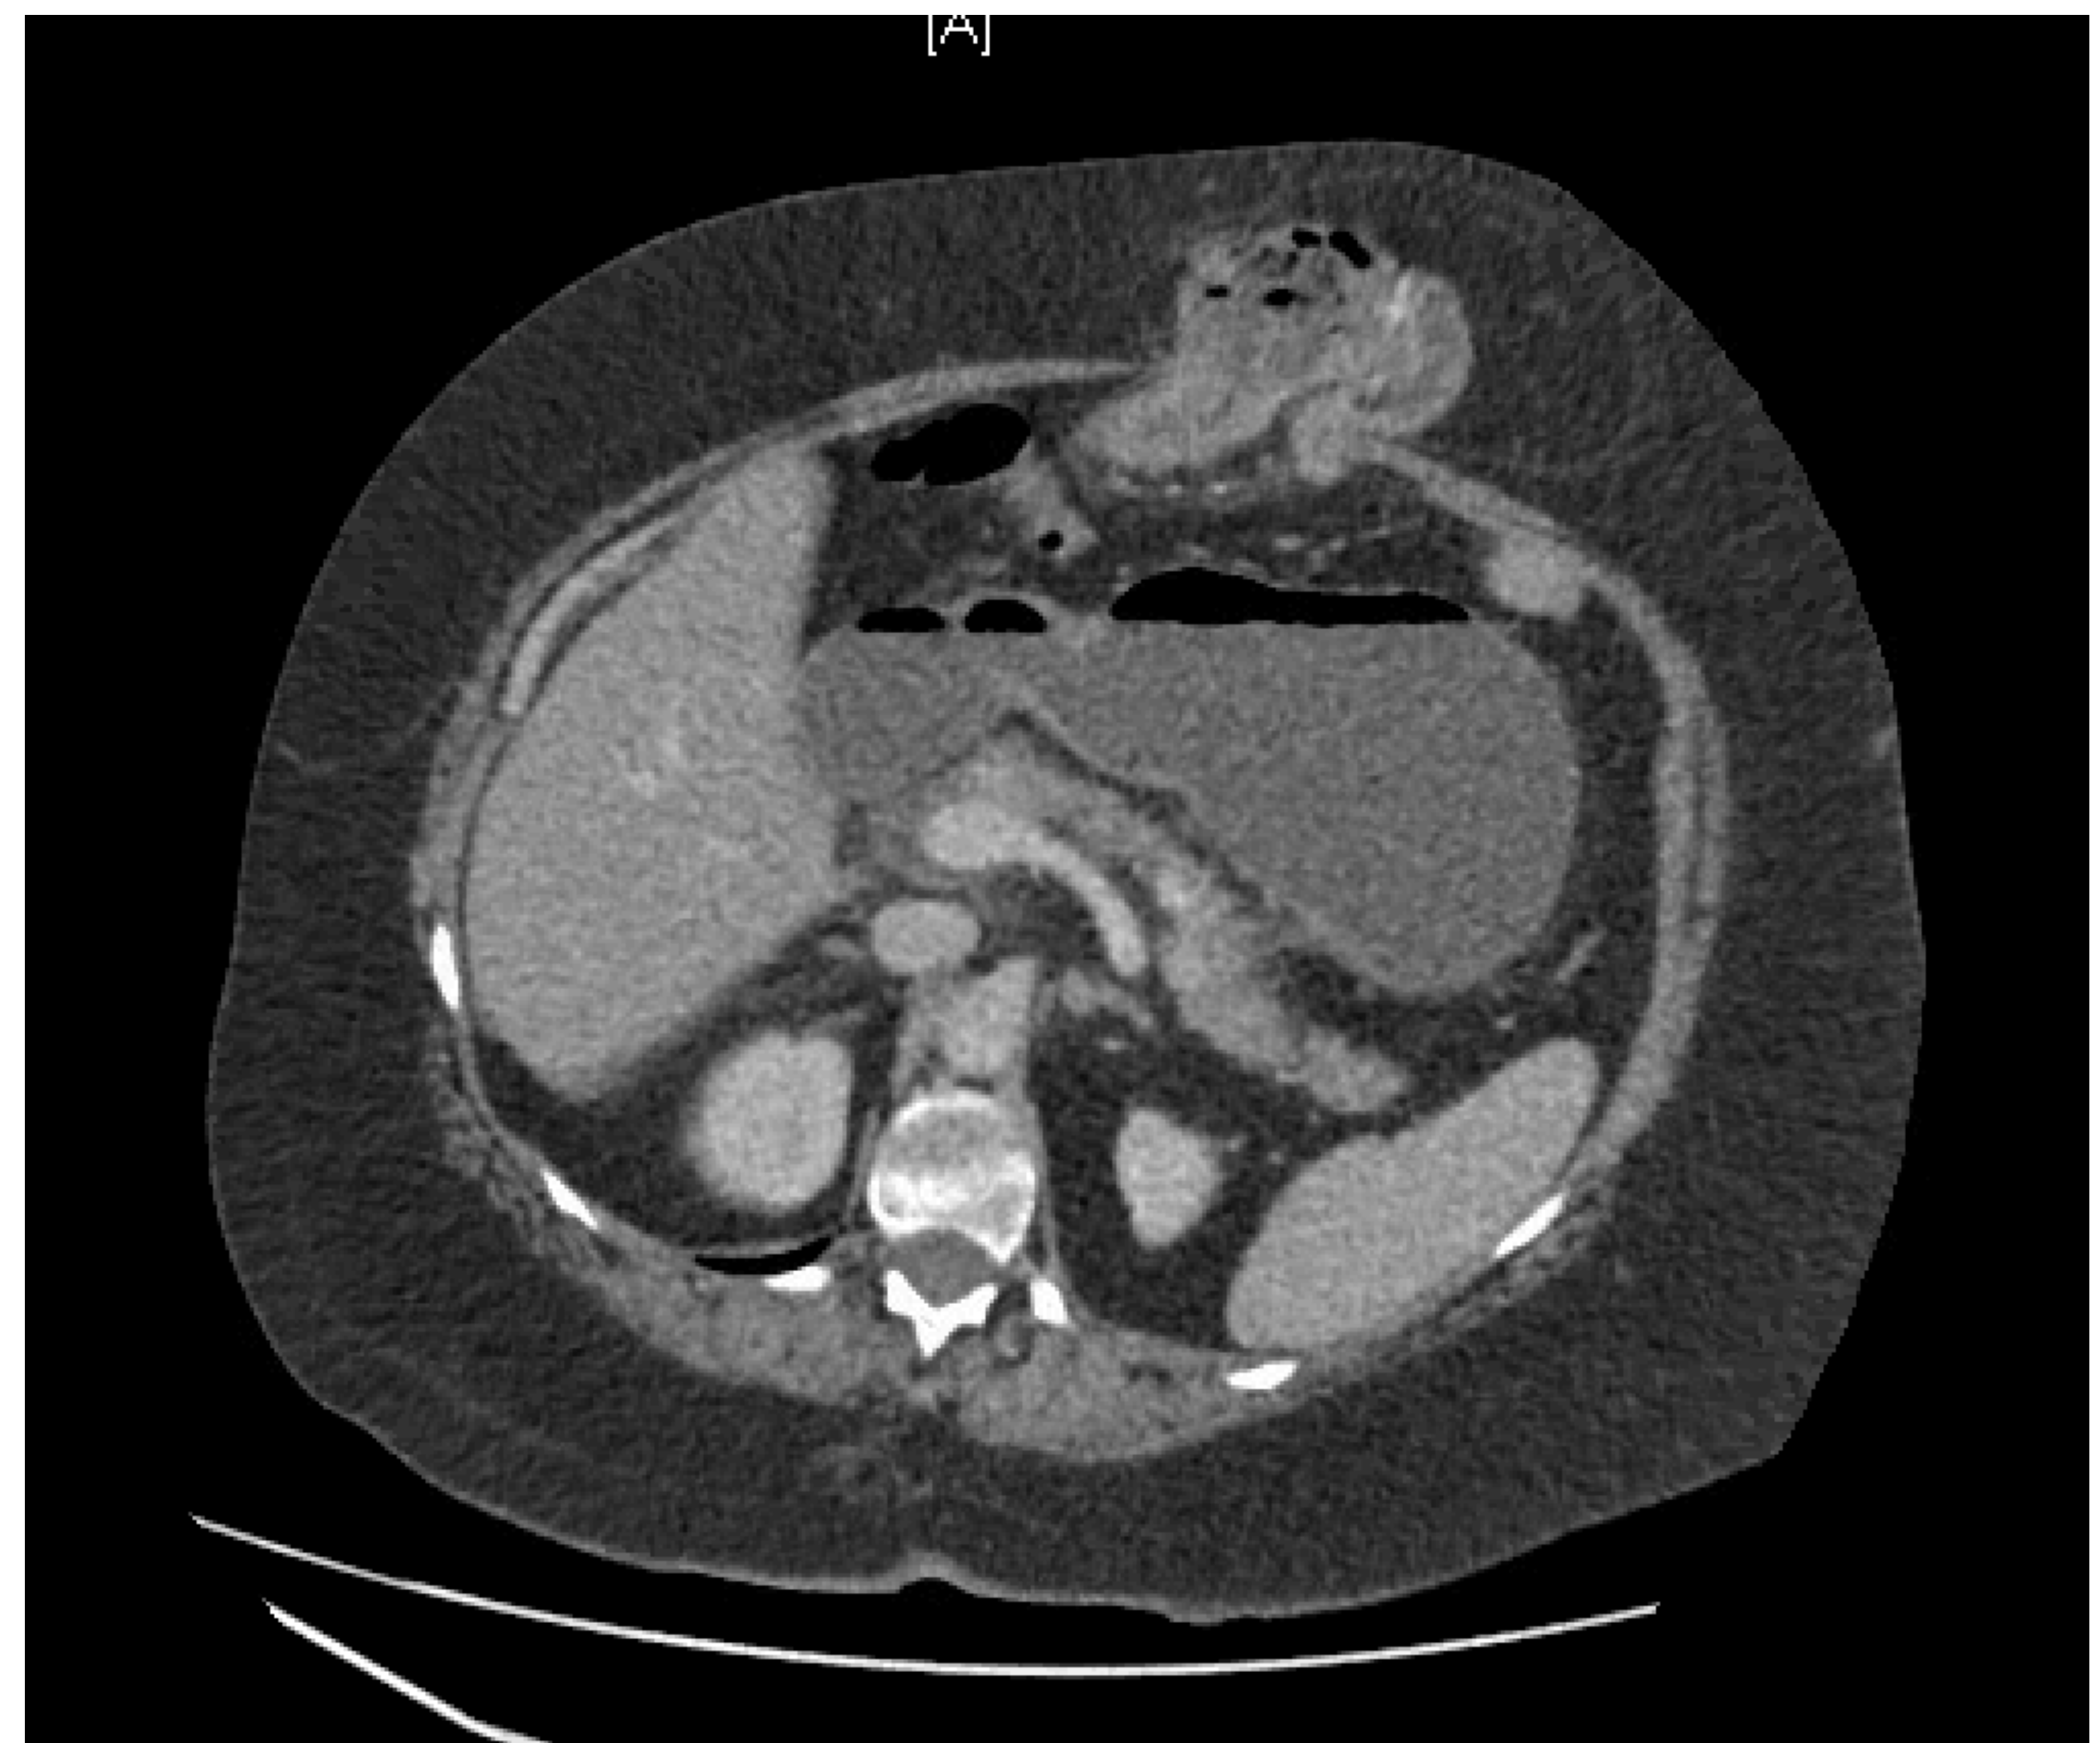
CT scan showing 1.) intestinal obstruction within the hernia sac. 2.) the incisional hernia contains the JJ anastomosis of the Biliopancreatic limb. 3.) There is a closed loop bowel obstruction of the Biliopancreatic limb. 4.) There is evidence of acute pancreatitis
